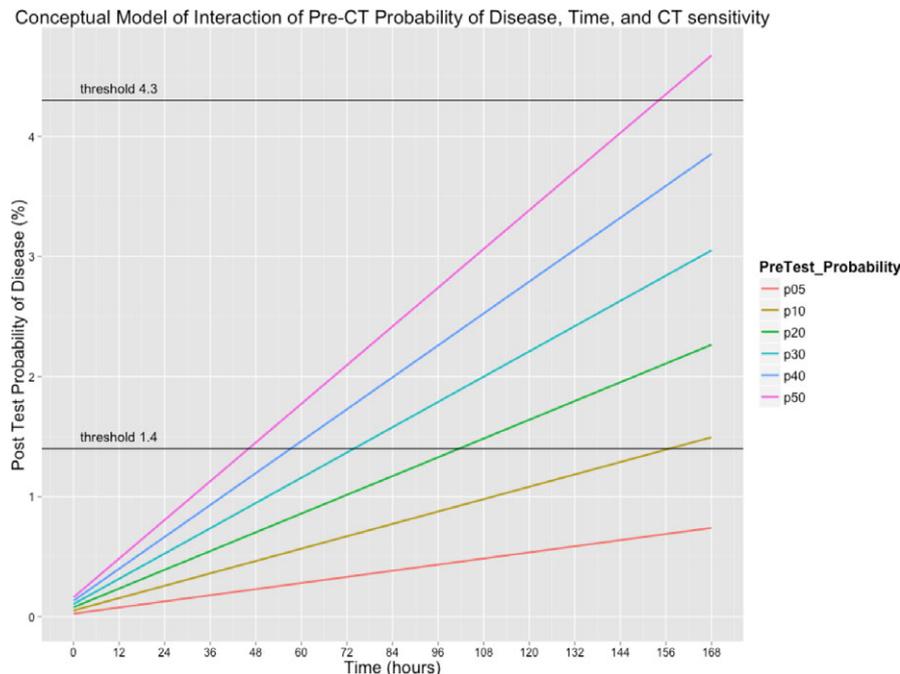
Conceptual model showing interaction of pre-CT probability of disease, time from onset of headache, and sensitivity of CT for SAH. Assumed linear decrease in CT sensitivity of 5% every 12 hours and constant specificity of 99%. Lower 95% bound (1.4) and mean value (4.3) of testing threshold are displayed. The intersection of the threshold and probability lines represent time points before which, according to our analysis, performing an LP causes more harm than good for a given pretest probability of disease. CT = computed tomography; LP = lumbar puncture; SAH = subarachnoid hemorrhage.
